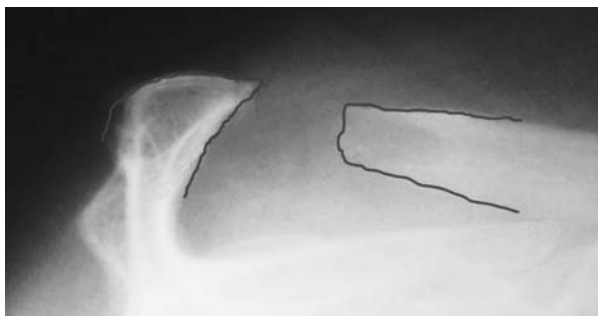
Outlet radiograph of a right shoulder showing excessive acromial resection. The red line outlines the edges of the resected acromion and the distal clavicle.
